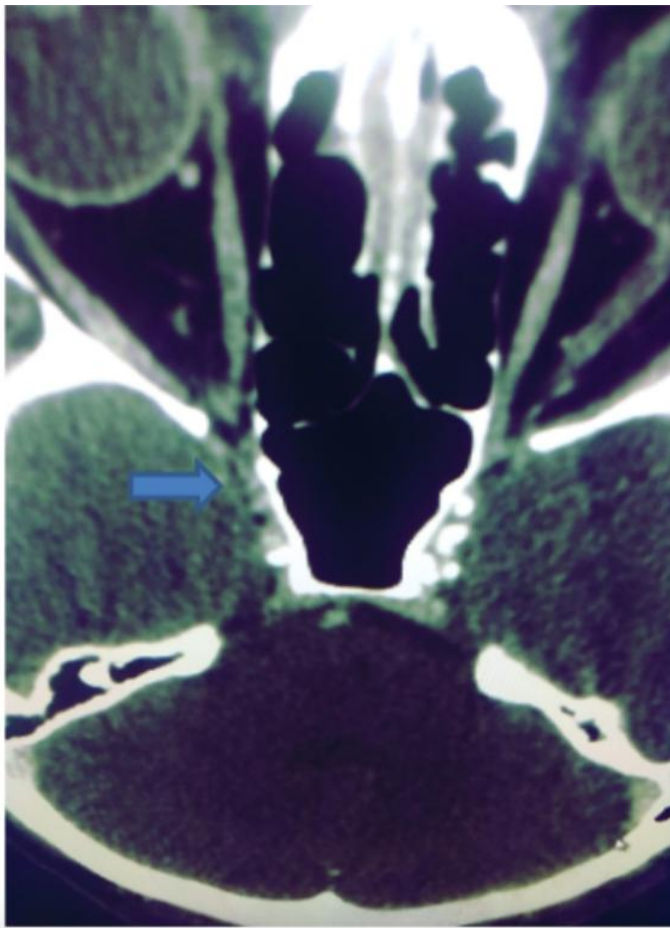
CT angiogram of the cerebral arteries; The blue arrow mark is the region depicting the stenosis of the right internal carotid artery in the supraclinoid segment
